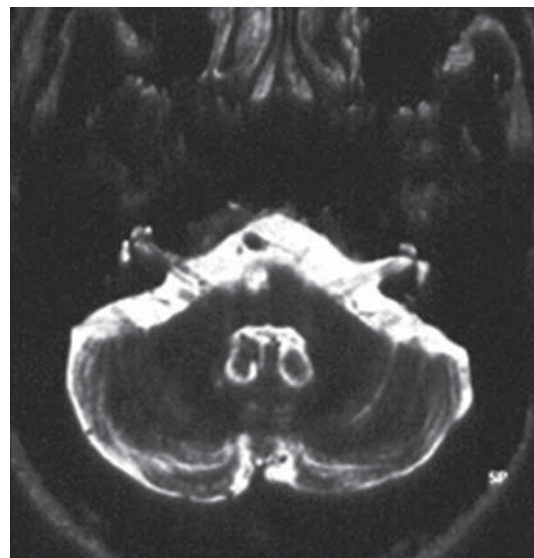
Same patient as in Figure 1. MRI demonstrates multiple hemorrhagic foci on the right pontomedullary junction.
